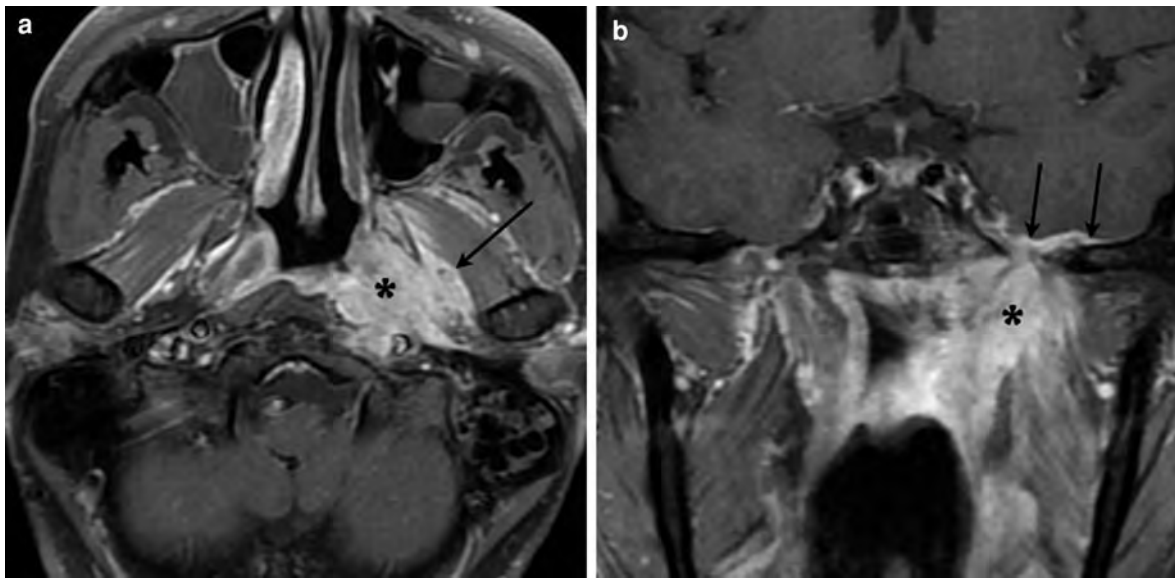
Nasopharyngeal carcinoma with perineural spread. a Axial contrast-enhanced fat-saturated T1-weighted MR image shows a left-sided nasopharyngeal carcinoma (*asterisk*) that spreads laterally across the parapharyngeal space to invade the left masticator space (*arrow*). b Coronal contrast-enhanced
